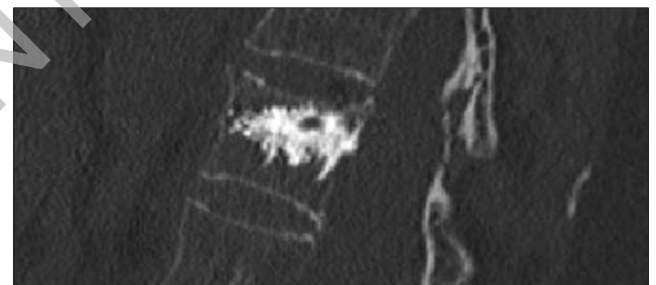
Sagittal CT view in a 71-year-old female patient with back pain showing a vertebral fracture of the body of D11. She had a symptomatic vertebral fractures without neurological impairment. A classical conservative management with brace was not possible for impairment of the general conditions.
